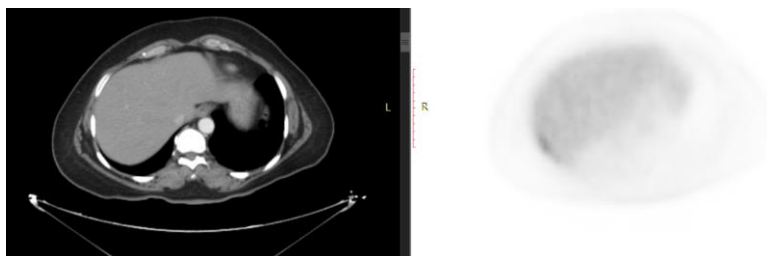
Images showing hepatic capsule peritoneal sheet of abnormal SUV max about 4.3, this abnormal uptake could be appreciated only in PET images.
